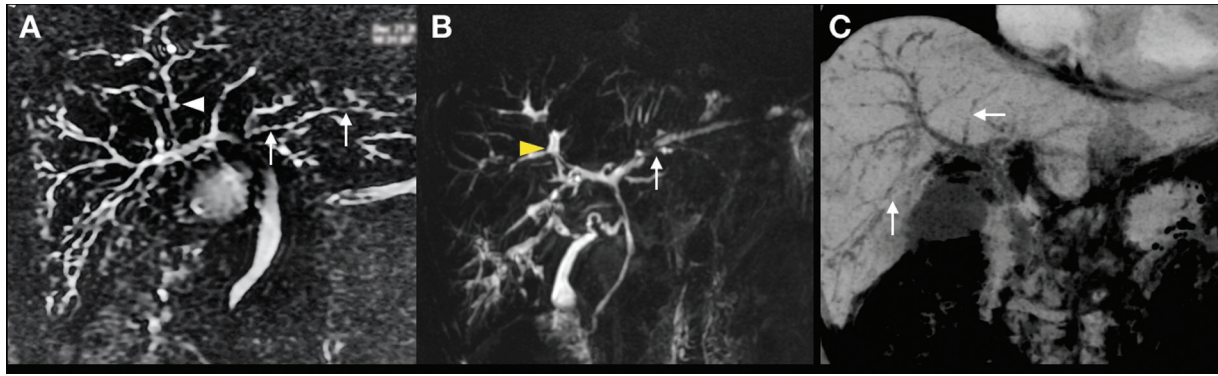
A 45-year-old male, a known case of ulcerative colitis, presenting with fatigue and pruritus. Coronal magnetic resonance cholangiopancreatography (MRCP) images (A, B) showing cholangiographic findings of primary sclerosing cholangitis (PSC) with short segment strictures and irregularities shown by small white arrows. White arrowhead in (A) showing tiny diverticulae. Yellow arrowhead in (B) showing loss of acute angle at biliary branching. Note irregular outline of the biliary radicles and visualization of biliary radicles up to the periphery of liver. (C) Computed tomography (CT) with minimum intensity projection (MinIP) showing irregular dilatation of the bile ducts with small focal band-like strictures.
